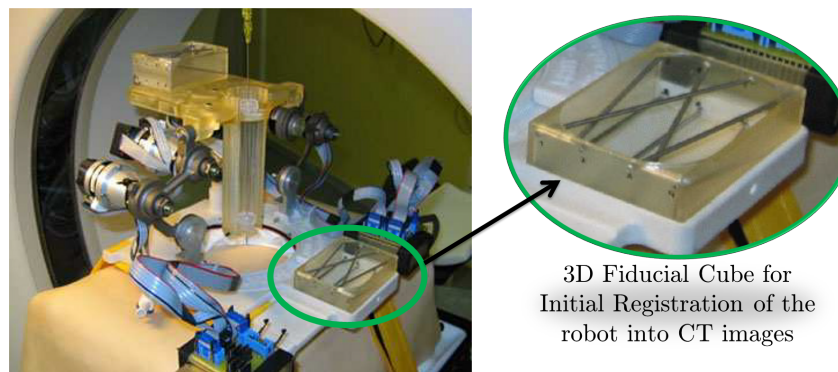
Prototype of CT-bot under test [1212, 1313].
